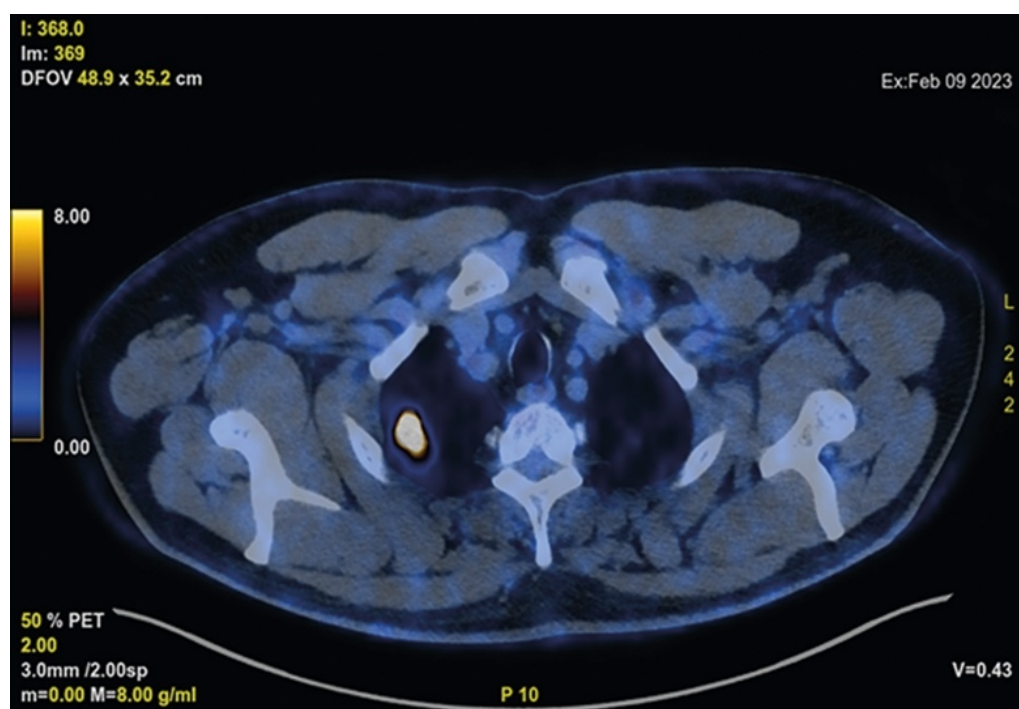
Positron emission tomography (PET)-computed tomography (CT) with highly active pulmonary nodule in the right apical upper lobe.
